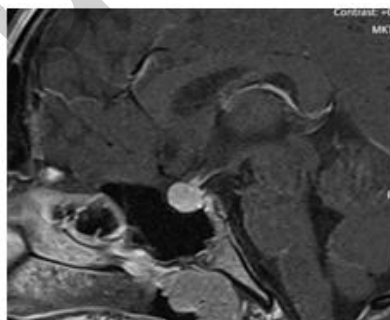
Sagittal T1-weighted MRI showing; image of a 6 X 3.4 mm mass in the pituitary gland at the first year of cabergoline treatment
